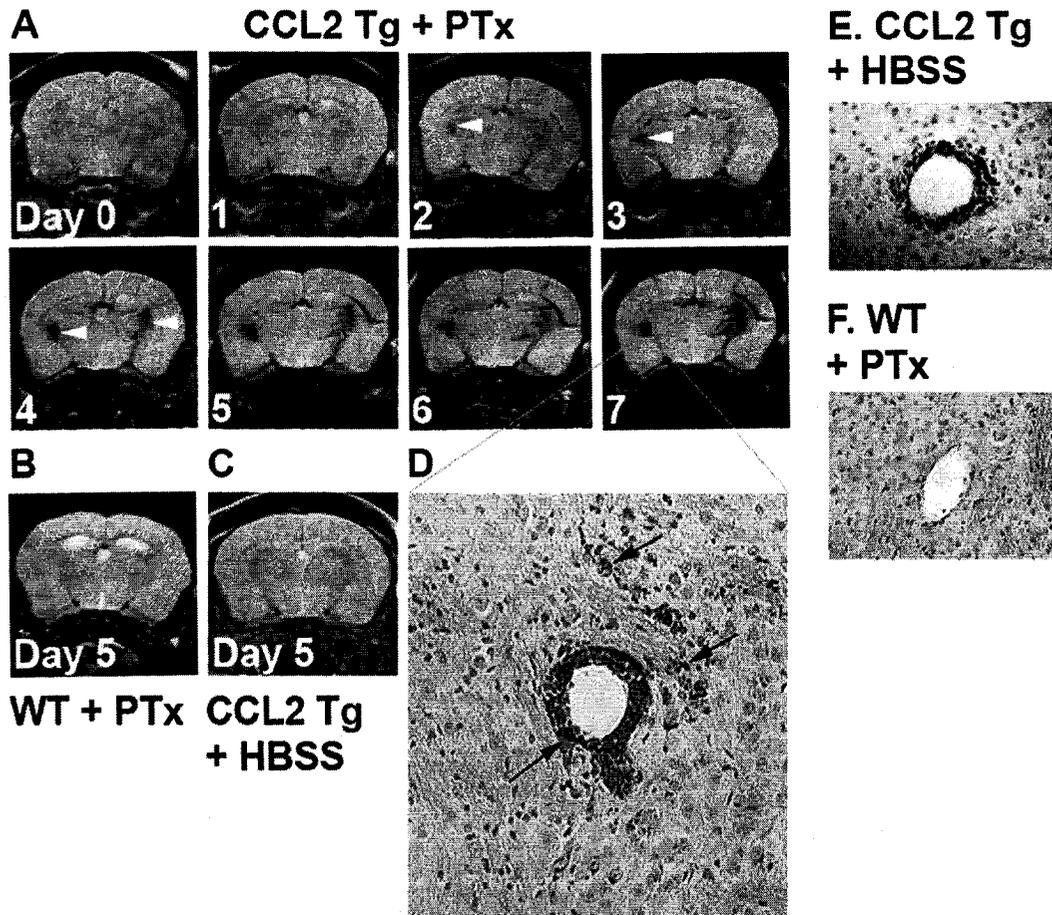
USPIO-enhanced MRI.
